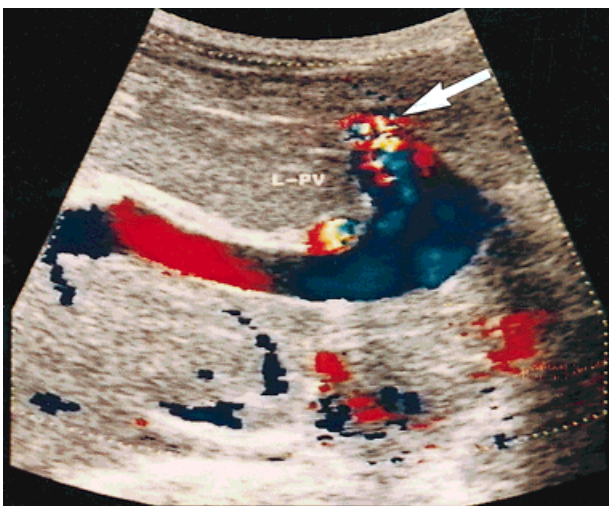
Color Doppler sonogram of the portal vein aneurysm. The flow in the left portal vein (L-PV) is reversed, and there is turbulence (arrow) at the distal portion of the aneurysmal sac.
